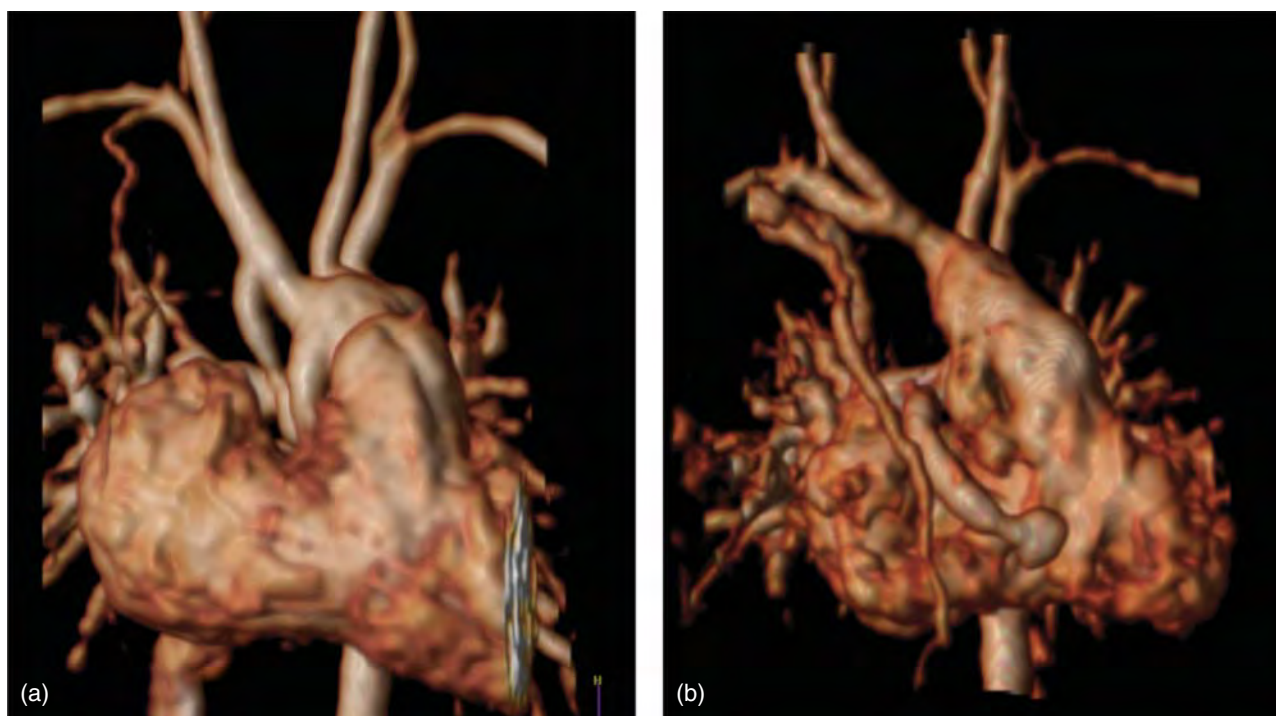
MRI prior to superior cavopulmonary anastomosis in a patient after: (a) classic Norwood; and (b) Sano modification.
